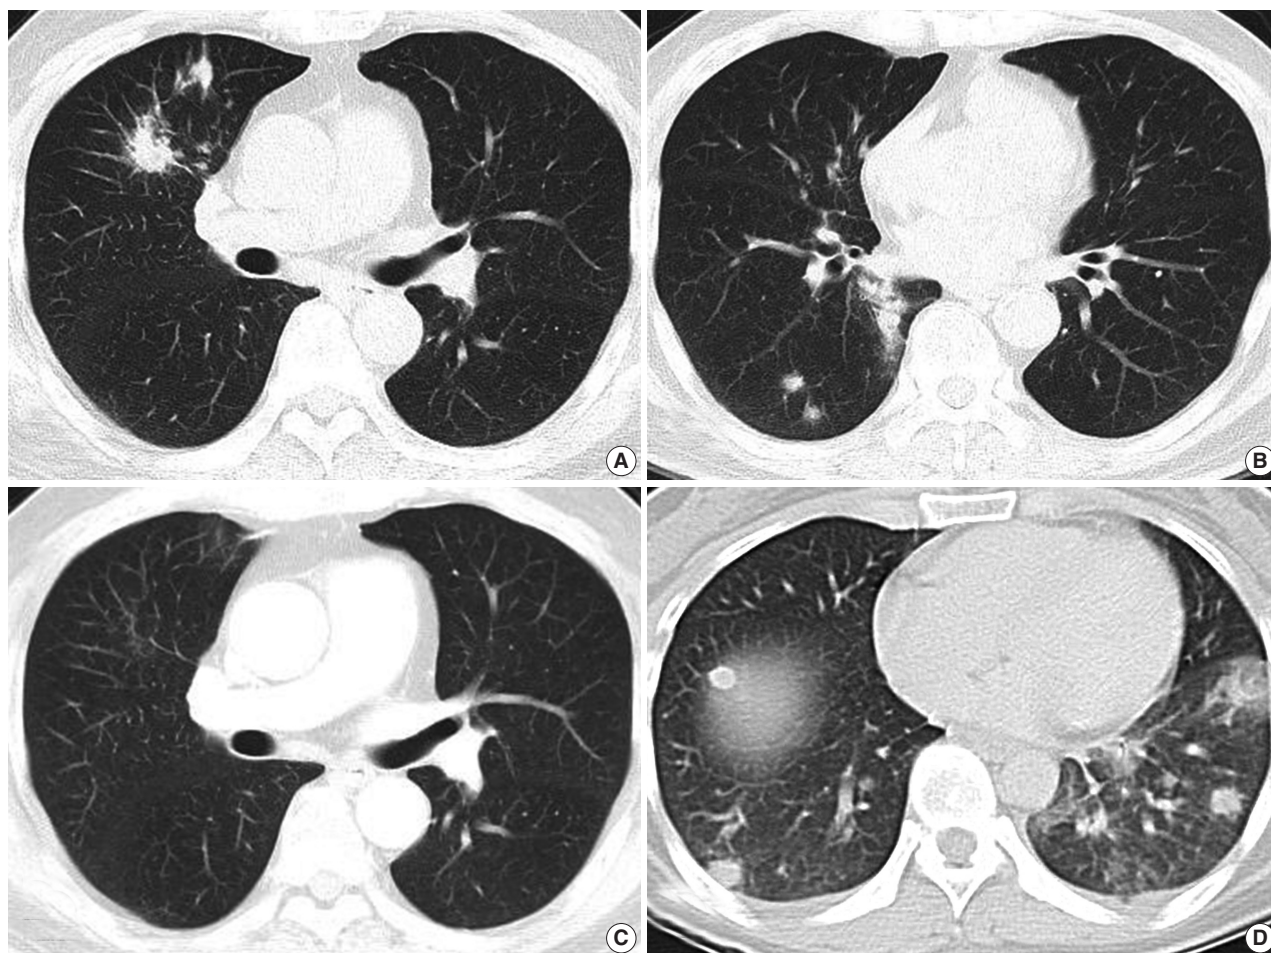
Radiologic findings. (A, B) Computed tomography (CT) of case 1 shows multiple variably-sized nodular lesions with hilar node enlargement. (C) Follow-up CT after one month of corticosteroid therapy reveals dramatic resolution. (D) CT of case 2 also reveals multiple ill-defined nodules.
